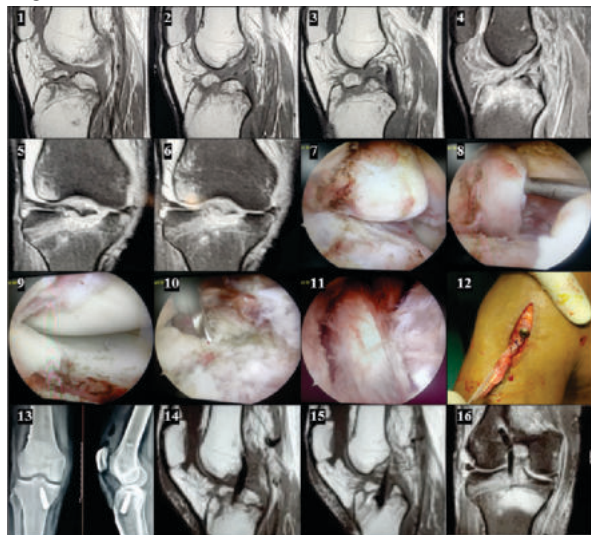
Images 1-6 are of pre-operative MRI scan showing displaced tibial spine avulsion fracture and altered interstitial signal of ACL. Images 7 shows arthroscopy finding of bunched up ACL attached to the displaced tibial spine avulsion fracture. Image 8 shows arthroscopy finding of lax and bruised ACL on probing. Image 9 shows the displaced tibial spine avulsion fracture and its bed. Image 10 shows arthroscopy picture of the tibial guide wire coming out into the tibial intercondylar area after removal of ACL and some of the tibial spine avulsion fracture fragment. Image 11 shows arthroscopy picture of the reconstructed ACL. Image 12 shows the interference screw fixing the STG graft in the tibial tunnel. Image 13 shows post-operative x-ray after ACL reconstruction. Images 14-16 are of post-operative MRI scan pictures after ACL reconstruction. These post-operative x-ray and post-operative MRI scans show that large portion of the avulsed tibial spine fracture fragment is left behind to heal to its bed and the reconstructed ACL lies fully behind the large tibial spine fracture fragment.
